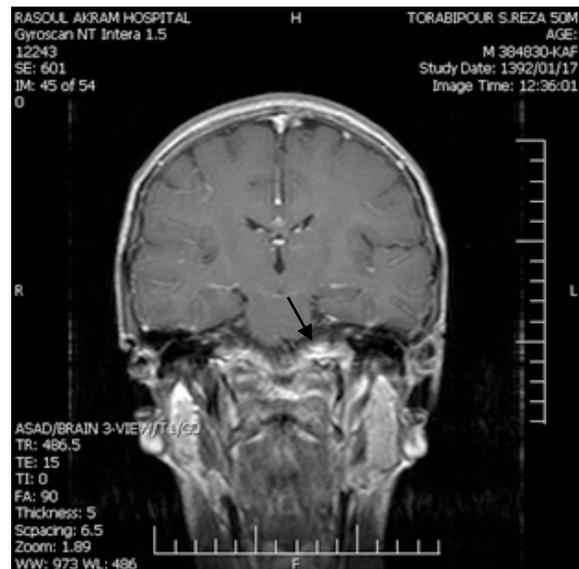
Coronal T1W MRI with GD shows enhancement of leptomeninges (arrowhead) and complex of seventh and eighth cranial nerves (arrow).
